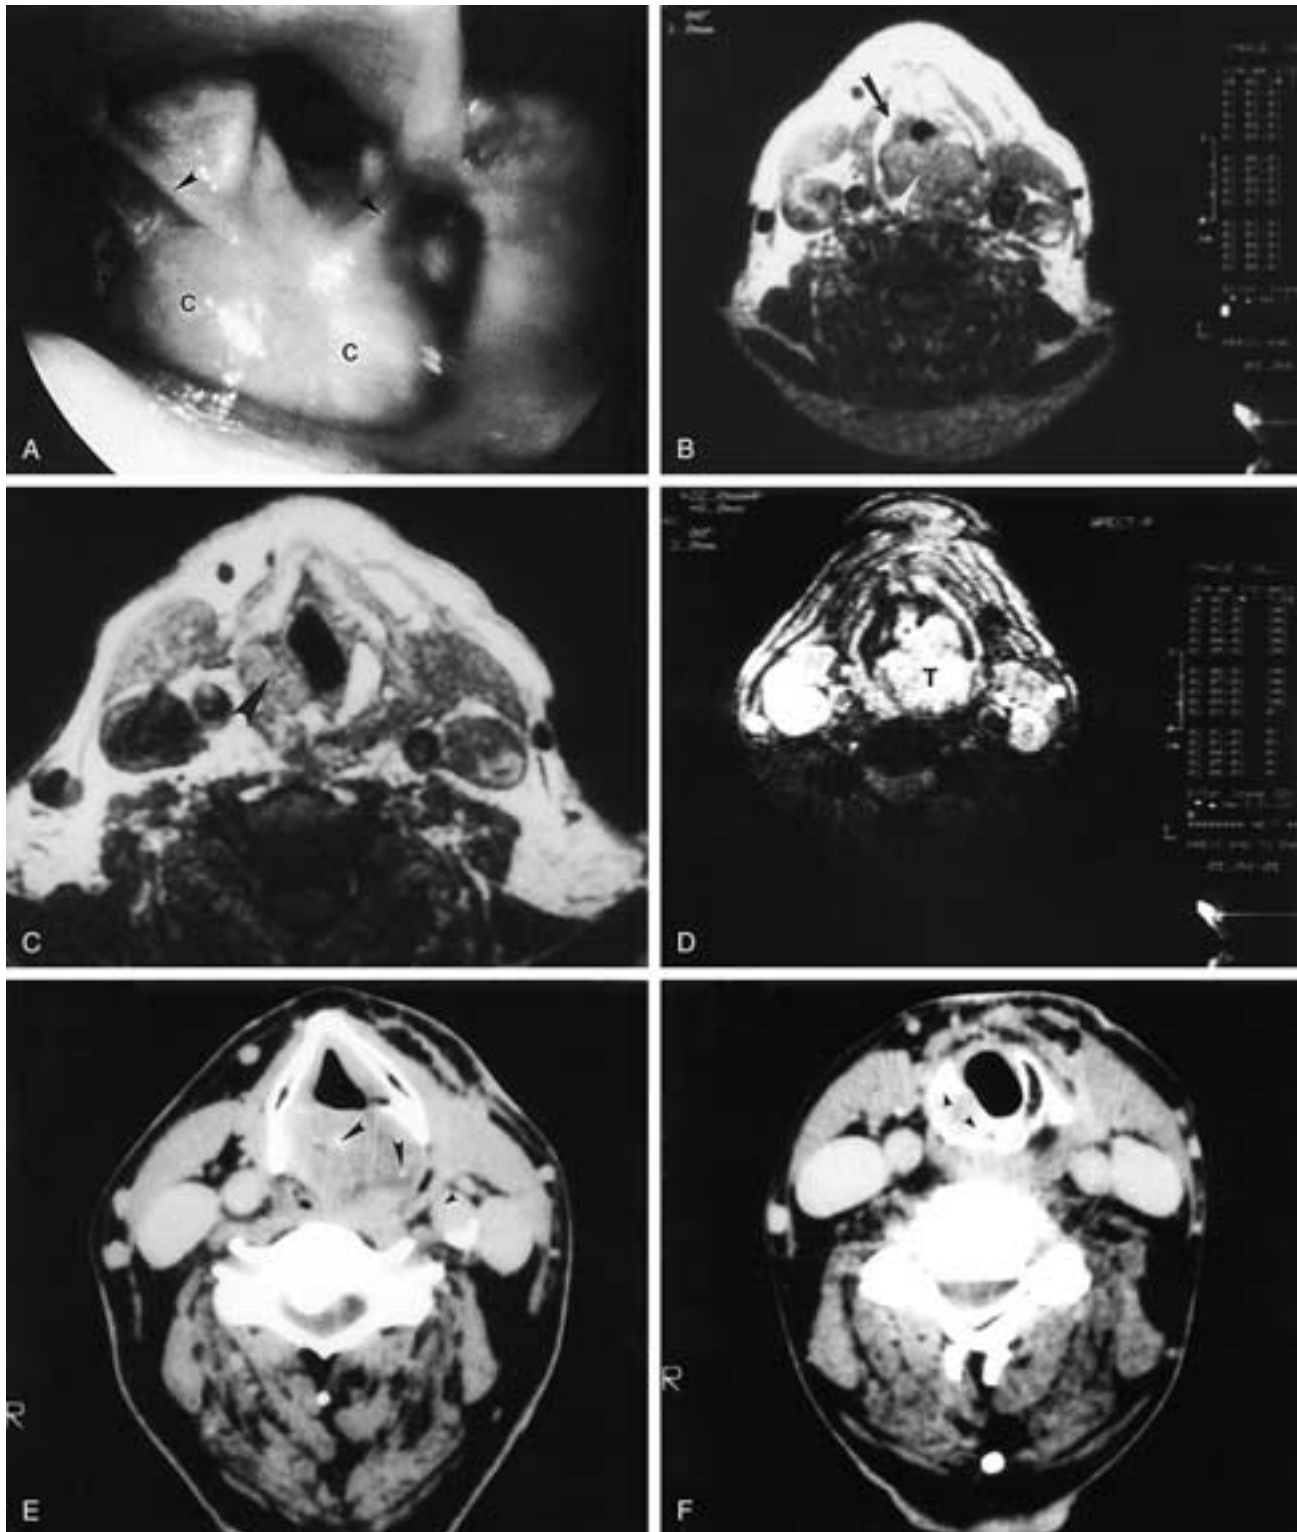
Chondrosarcoma of the larynx. A, Endoscopic view shows a large bulge in the region of the cricoid (C). Note that the mucosa is intact and is not ulcerated. *Arrowheads*, AE folds. B, T1-weighted image shows the large submucosal mass (*arrowhead*). Note its position in the posterior larynx. There is no abnormality in the paraglottic fat (*arrow*). C, Slightly lower than B. Axial image through the cricoid cartilage shows a well-defined defect (*arrowhead*). The sharp margin would be unusual in invasion by squamous carcinoma. This indicates the origin within the cricoid cartilage. D, T2-weighted axial image shows the tumor (T) to have the high signal characteristic of chondrosarcoma. E, Axial CT shows a large mass with small punctate calcifications (*arrowheads*). This suggests the chondroid nature of the lesion. F, Axial scan through the cricoid shows the sharp margin of the lesion (*arrowheads*) as it abuts the normal cartilage.
